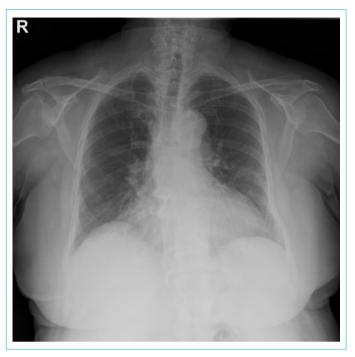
Chest X-ray in 7 days during the treatment of the patient (withdrawn to bed).
